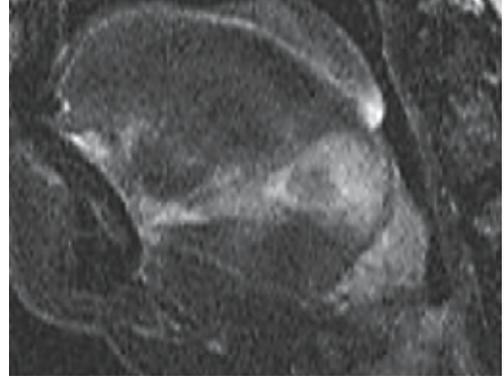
Radiofrequency lesion and perifocal edema in the MRI (TIRM sequence)
